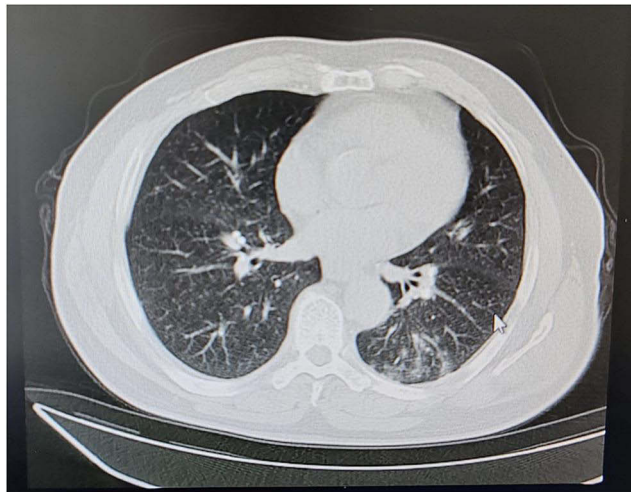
Widespread lesions in both lungs on chest CT.
